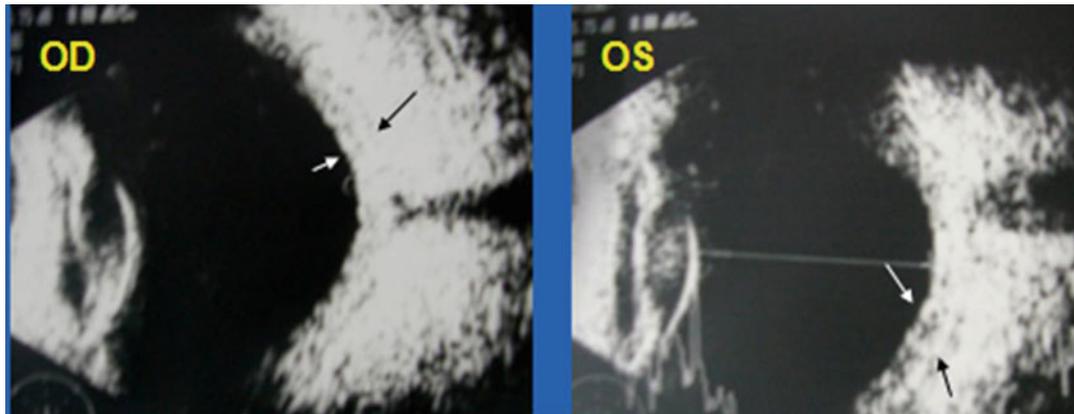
Ultrasonography revealed bilateral retinochoroidal thickening seen as increased thickness between the hyper reflective retina (*white arrow*) and the posterior layers of choroid (*black arrow*)
